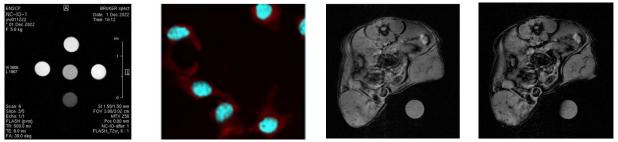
MRI- images of contrast agents and in vitro/in vivo micro images, IA imaging process
